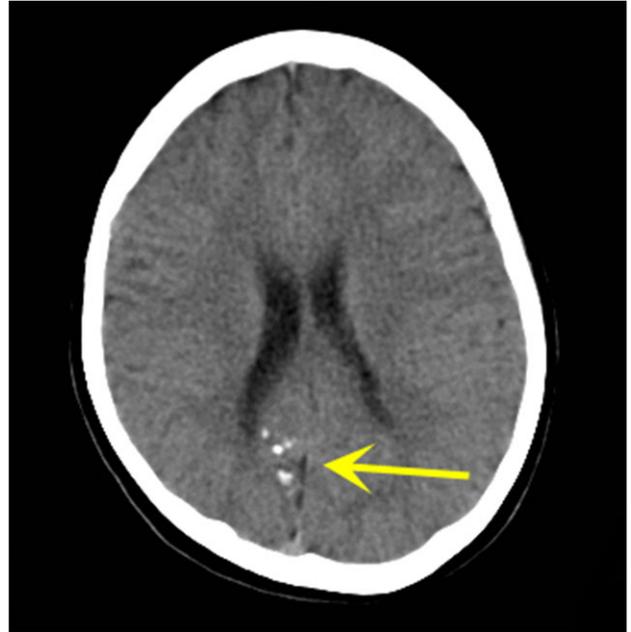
Right occipital intracerebral calcifications on preoperative CT.
